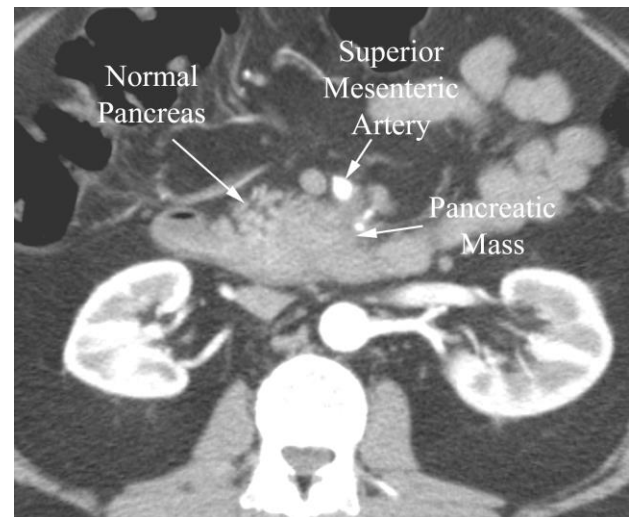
Pancreatic cancer in a 43 year old man with weight loss and abdominal pain. Axial CT performed during the arterial phase demonstrates tumor in the pancreas effacing the normal lobulated (with fat) appearance. The tumor surrounded the superior mesenteric artery more superiorly (not shown).
